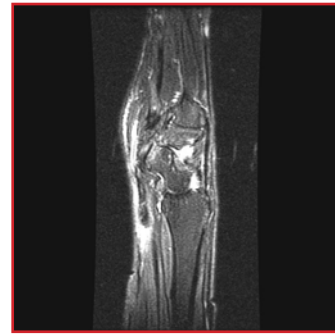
Postoperative magnetic resonance imaging at 4 months in case 1, showing left wrist after the patient fell and re-injured her left thumb, with complete rupture of the flexor carpi radialis and with retraction to the level of the wrist.
